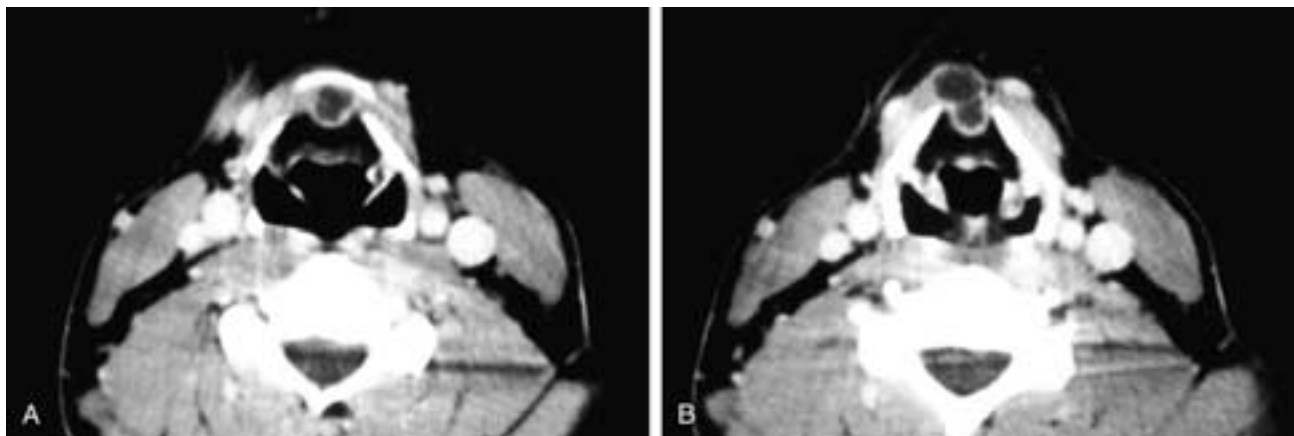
Axial contrast-enhanced CT scans at the cranial level (A) and a more caudal level (B). There is a slightly lobulated midline cyst that extends from the lower posterior margin of the hyoid bone (A), indents the thyrohyoid ligament, and projects into the superior thyroid notch of the thyroid cartilage of the larynx (B). Such a thyroglossal duct cyst was an incidental finding on this scan of the neck done for another reason. These cysts indent the thyrohyoid membrane but do not actually enter the preepiglottic space of the larynx.
